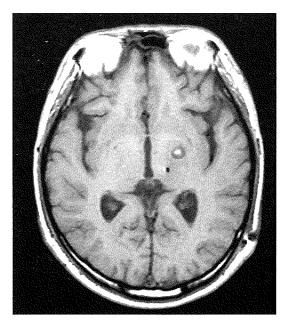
Patient 1. Axial T1-weighted MRI 7 days after surgery showing the coagulative lesion made by the left globus pallidus internus pallidotomy and the deep brain stimulation lead more posteriorly in the left ventral intermediate nucleus of the thalamus.
